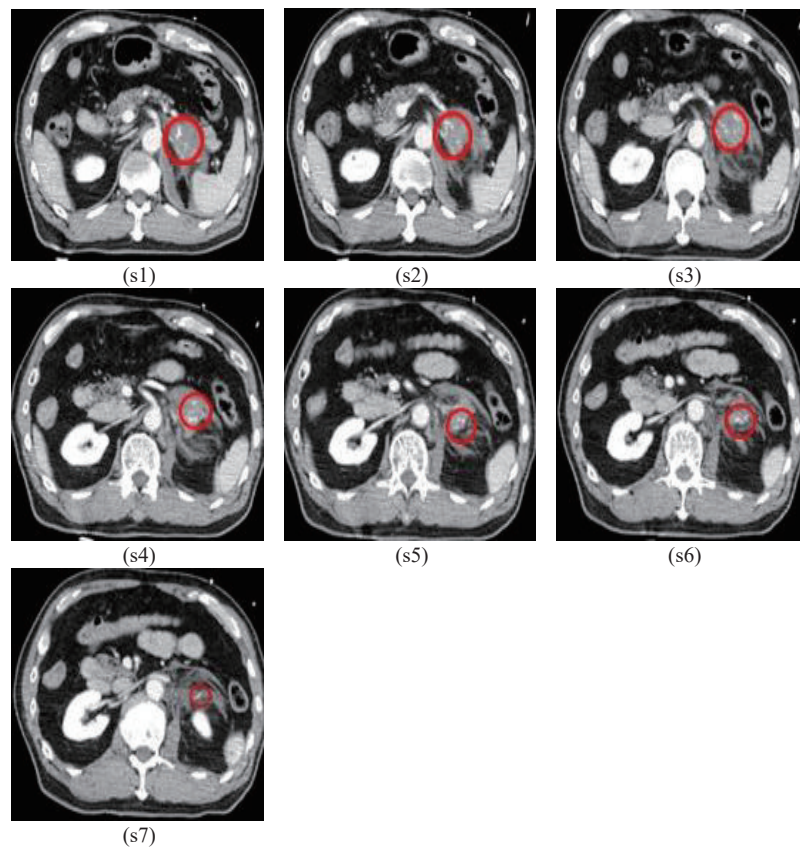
Sequential CT showing extravasation (marked with circles) in a retroperitoneal hematoma, where s_1, \dots, s_7 indicate slice #1, \dots , slice #7.
